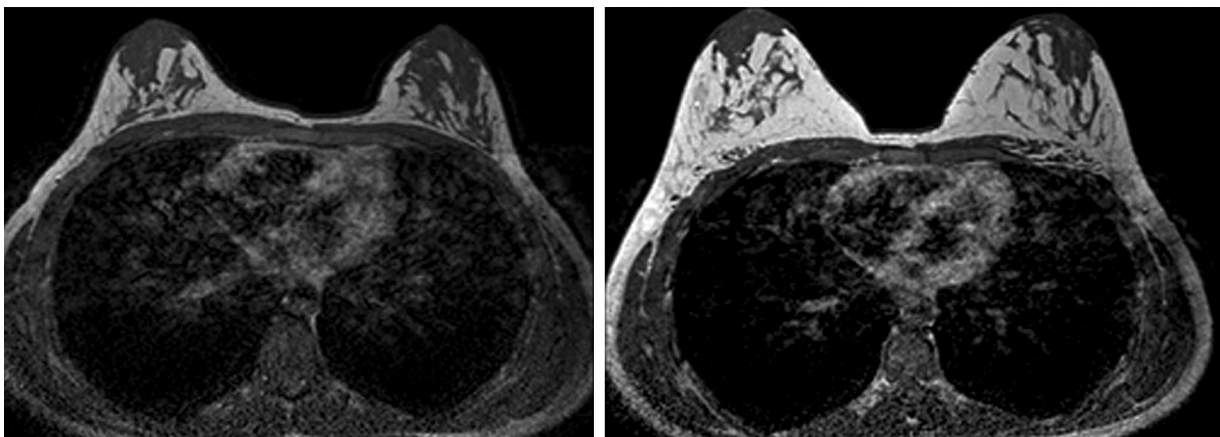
Representative magnetic resonance imaging scans from the series. Tissue contributing to increased volume is consistent with viable fat. There are no cysts, masses, or fat necrosis.
